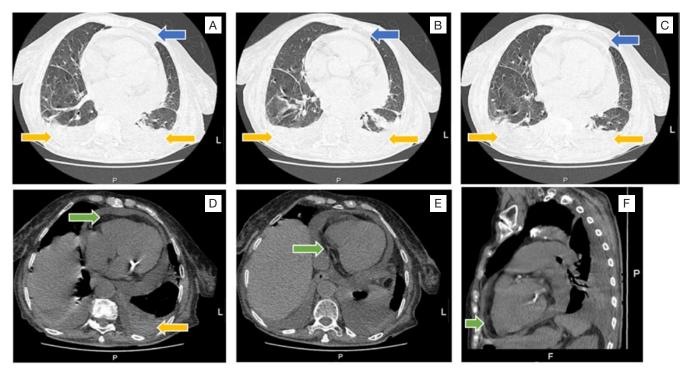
(A), (B) and (C) Computed tomography angiography using pulmonary view showing bilateral pleural effusion (yellow arrows) and parenchymal condensation of the lingula (blue arrow). (D), (E) and (F) Computed tomography angiography using mediastinal view showing circumferential pericardial effusion (green arrows) and pleural effusion (yellow arrow) (F - Front, L - Left, P - Posterior).
